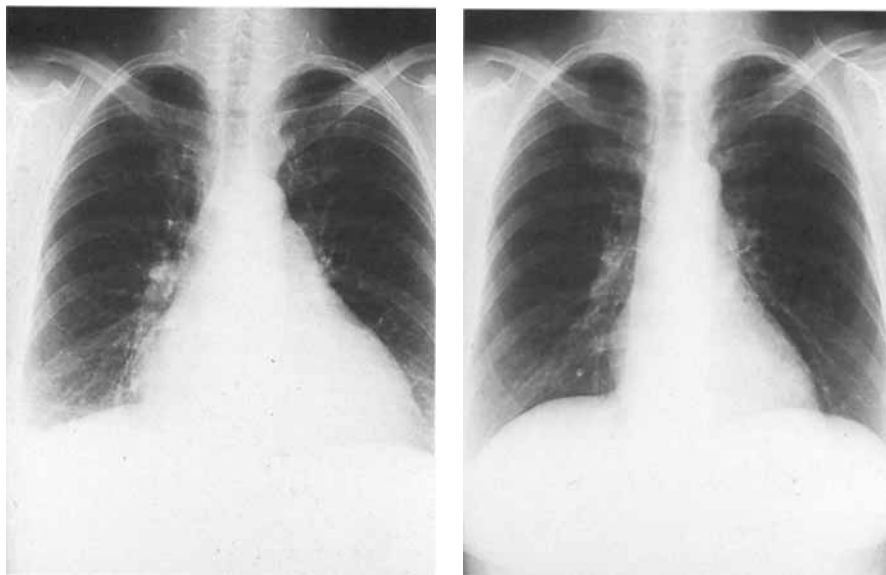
Interferon-related cardiomyopathy in a 41-year-old woman with stage IV non-Hodgkin's lymphoma. The patient developed congestive heart failure after 8 months of IFN- α treatment at a dose of 3×10^6 IU three times per week (panel A). The increased cardiac silhouette was shown by echocardiography to be due to left ventricular enlargement. After withdrawal of IFN and treatment with digoxin and furosemide, cardiac symptoms rapidly improved and a control chest radiograph showed a normalization of heart size (panel B). The patient remained free of cardiovascular symptoms until her death 8 months later from progressive non-Hodgkin's lymphoma
